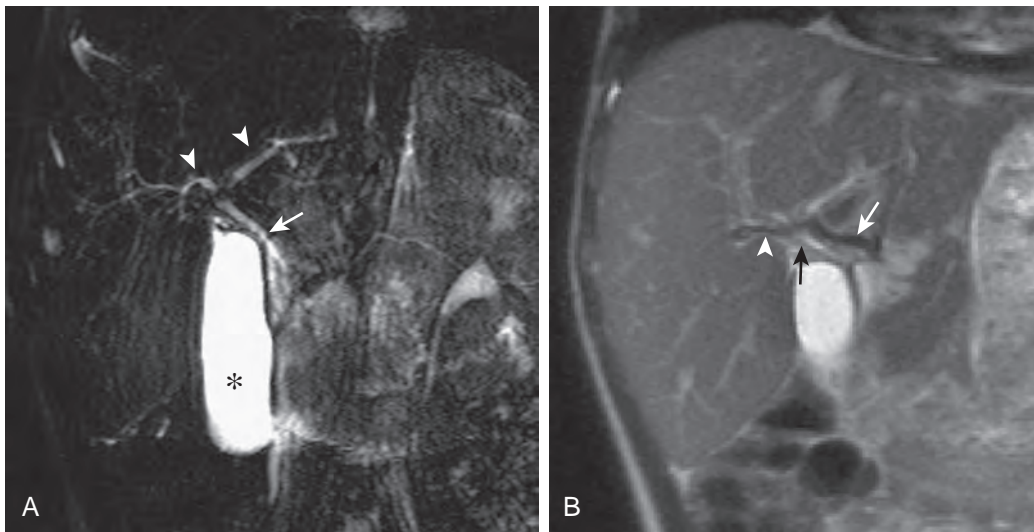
Normal findings on MRCP. MRCP was obtained to evaluate the biliary tract in a child with sickle cell disease. A. The coronal, thick-slab, T2-weighted image demonstrates patency of the common bile duct (arrow), the common hepatic duct, and the right and left hepatic ducts (arrowheads). There is loss of signal where the hepatic artery crosses at the confluence of the right and left hepatic ducts. Individual source images (not shown) demonstrate duct patency. The gallbladder is distended with bile (asterisk). B. Coronal half-Fourier acquisition single-shot turbo spin-echo (HASTE) image demonstrates the flow void in the main hepatic artery (white arrow) and right branch of the hepatic artery (arrowhead). The black arrow marks the origin of the common hepatic duct.
